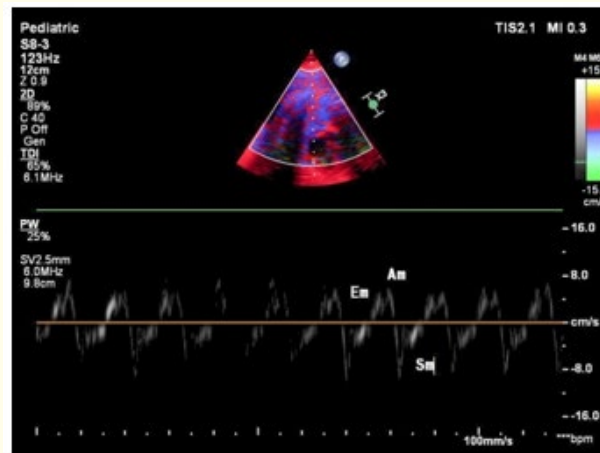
Tissue doppler echocardiography revealed atrial rate (Am) and ventricular A:V rate (Sm) of 211 with 1:1 association.
